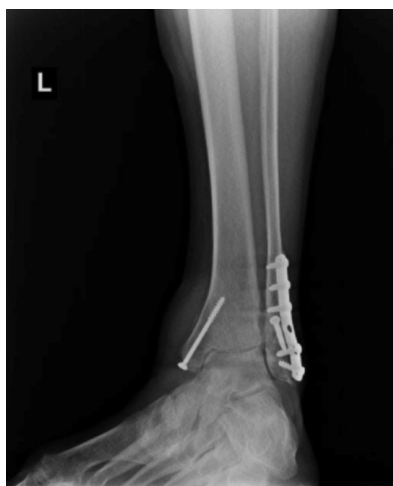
Ankle mortise view radiograph showing increase in soft tissue density without bone involvement.
